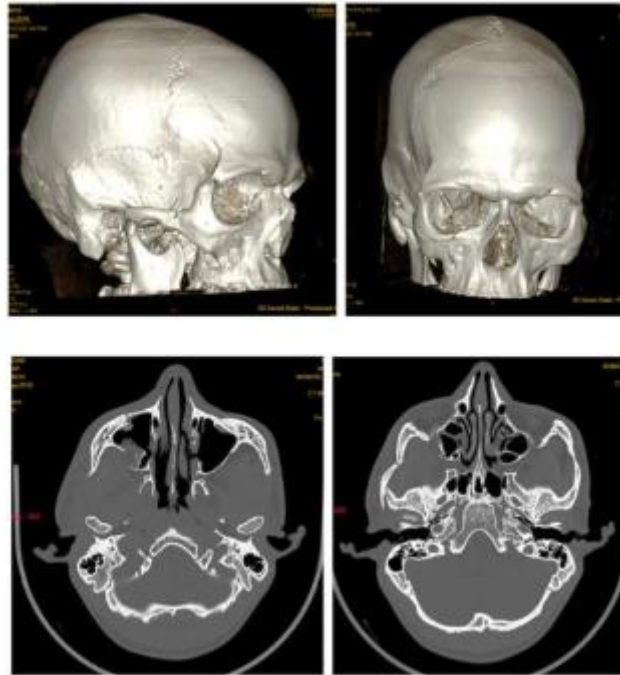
Sequence of images [3D-CT(A,B) and Axial images(C,D)] shows depressed fracture in the right Zygoma.
